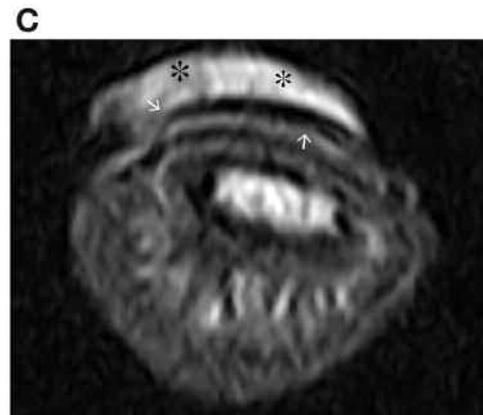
A. High-field magnetic resonance imaging (MRI) of the distal phalanx, fast-field echo (FFE) T1 3-D axial image, executed after applying petroleum jelly (asterisks) on the nail to identify its outer margin, in a control subject in which the axial plane allows exhaustive study of the nail, which appears as a physiologic low signal of regular shape and thickness (arrows). B. High-field MRI of the distal phalanx, FFE T1 3-D axial image, in a patient with psoriatic arthritis without a clinically evident onychopathy. Asterisks indicate outer margin of nail. The nail is asymmetrical-thickened (arrows). C. Low-field MRI of the distal phalanx, turbo spin echo T1 axial, in a patient with PsA with a clinically evident onychopathy. Asterisks indicate outer margin of nail. The nail is thickened with an irregular outer margin (arrows).
